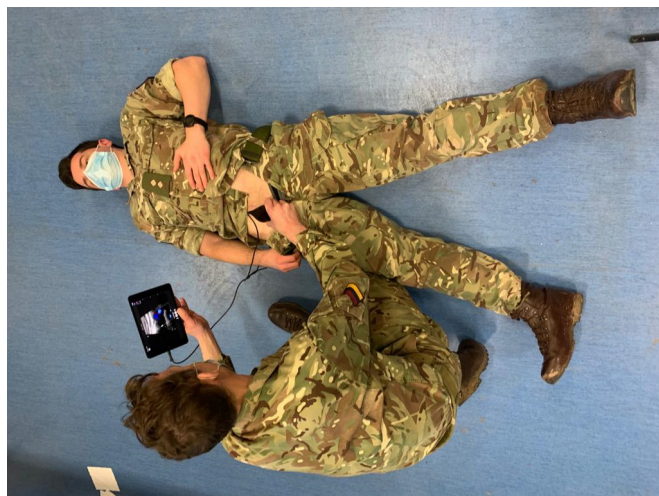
Consultant radiologist determines common femoral artery flow with hand-held ultrasound device.
